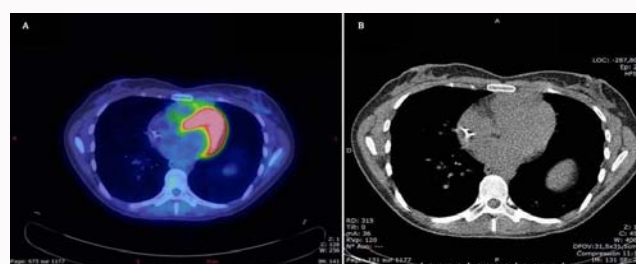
Imaging performed after chemotherapy. A) FDG-PET scan (obtained after five chemotherapy cycles) shows a complete remission with only a metabolically inactive anterior mediastinal lesion left; B) Low-Dose CT-scan (obtained after five chemotherapy cycles) shows the regression of the anterior mediastinal mass.
